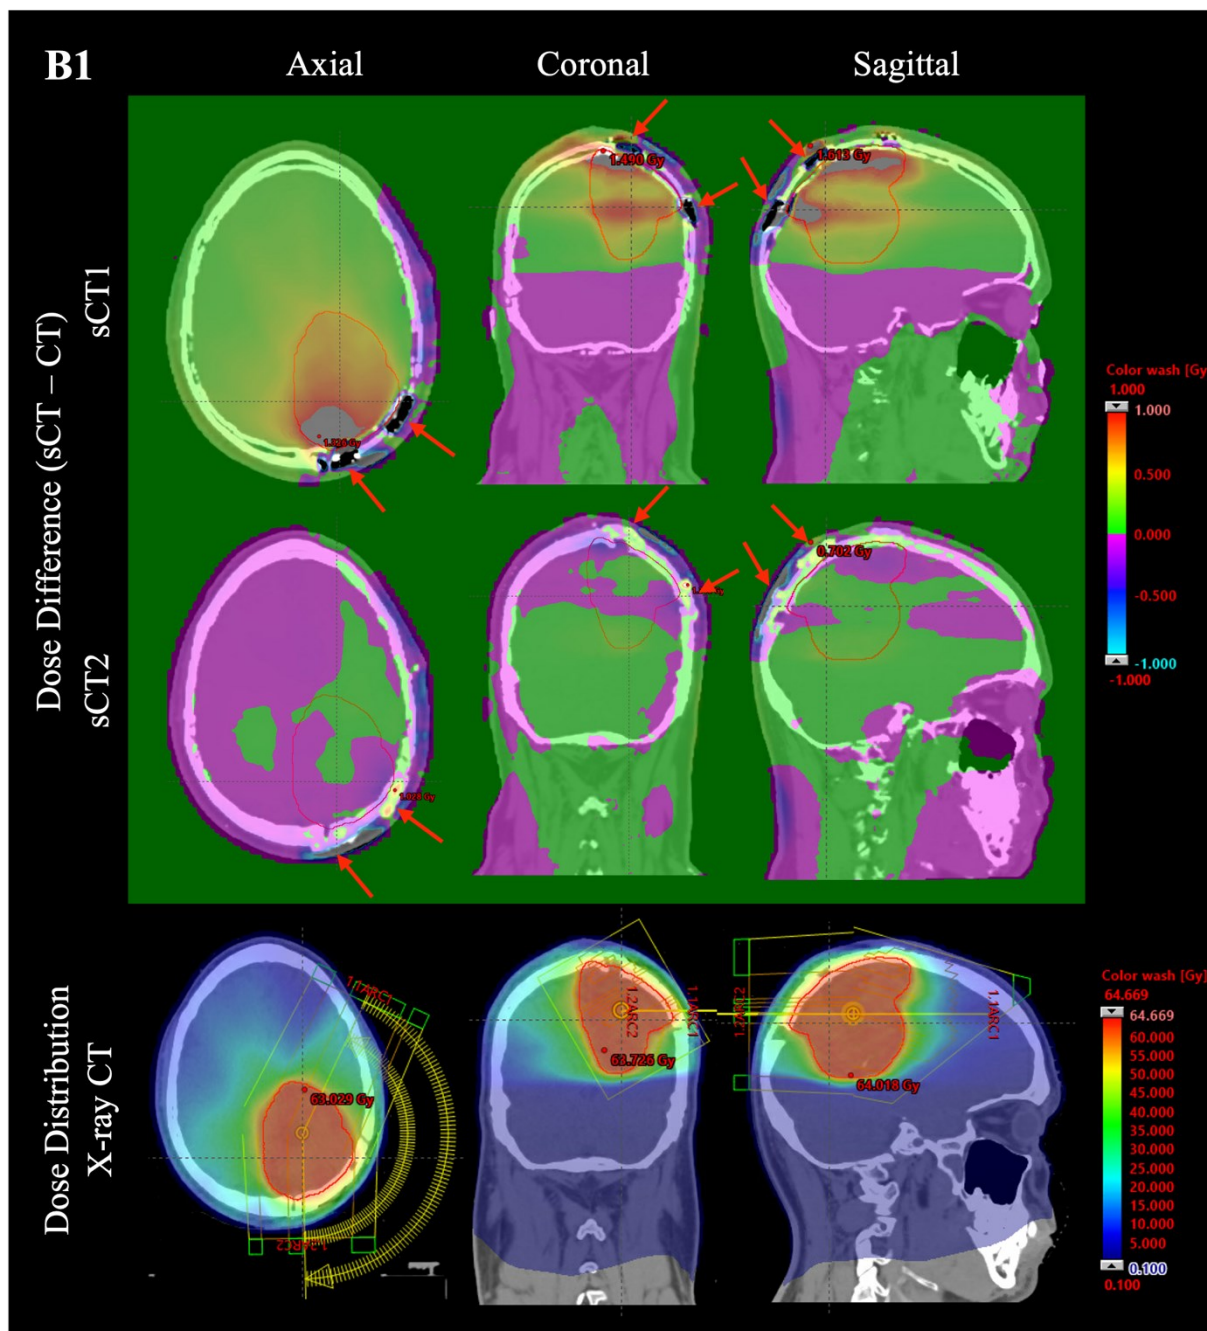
Dose difference maps for sCT1 (1st row) and sCT2 (2nd row), and dose distribution on X-ray CT (3rd row), for patient B1. Regions of Ti implants in X-ray CT are indicated by red arrows in the sCT images.
